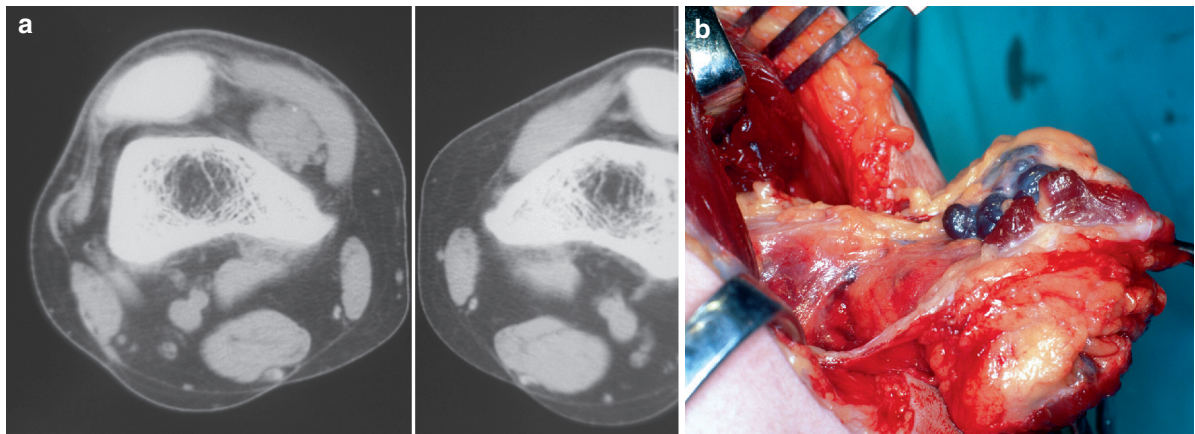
Intramuscular hemangioma of the vastus medialis obliquus muscle (a) CT image (b) Macroscopic appearance (Reproduced from Sanchis-Alfonso et al.⁴⁶, with permission)
